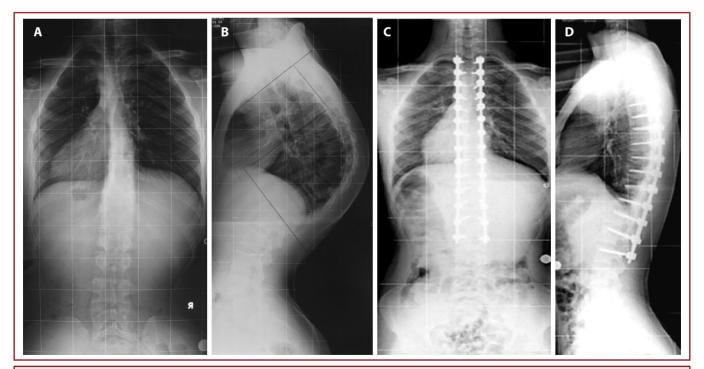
Patient number 2 was 27 years old male diagnosed hyperkyphosis complaint with cosmoses. Preoperative standing long cassette AP (A) and Lateral (B) radiograph was obtained. His thoracic kyphosis was79° and lumbar lordosis was 61°. Peroperative picture show SPO level and pedicle screw placement clinically (C). Control X-rays shows thoracic kyphosis was improved 79° to 42° after eight level SPO and pedicle screw placement only posterior approach (D,E).
